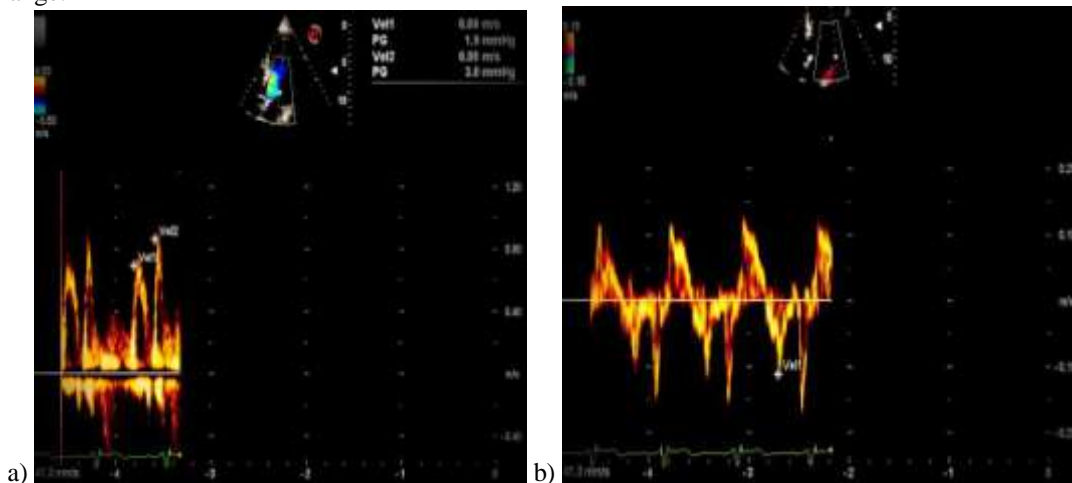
(a), On the left panel pulse wave doppler at the tip of mitral valve showed LV diastolic relaxation dysfunction (diastolic dysfunction grade 1), (b), On the right panel, tissue doppler Imaging of the LV estimated the E/E' ratio was 7:1 (within normal range).
